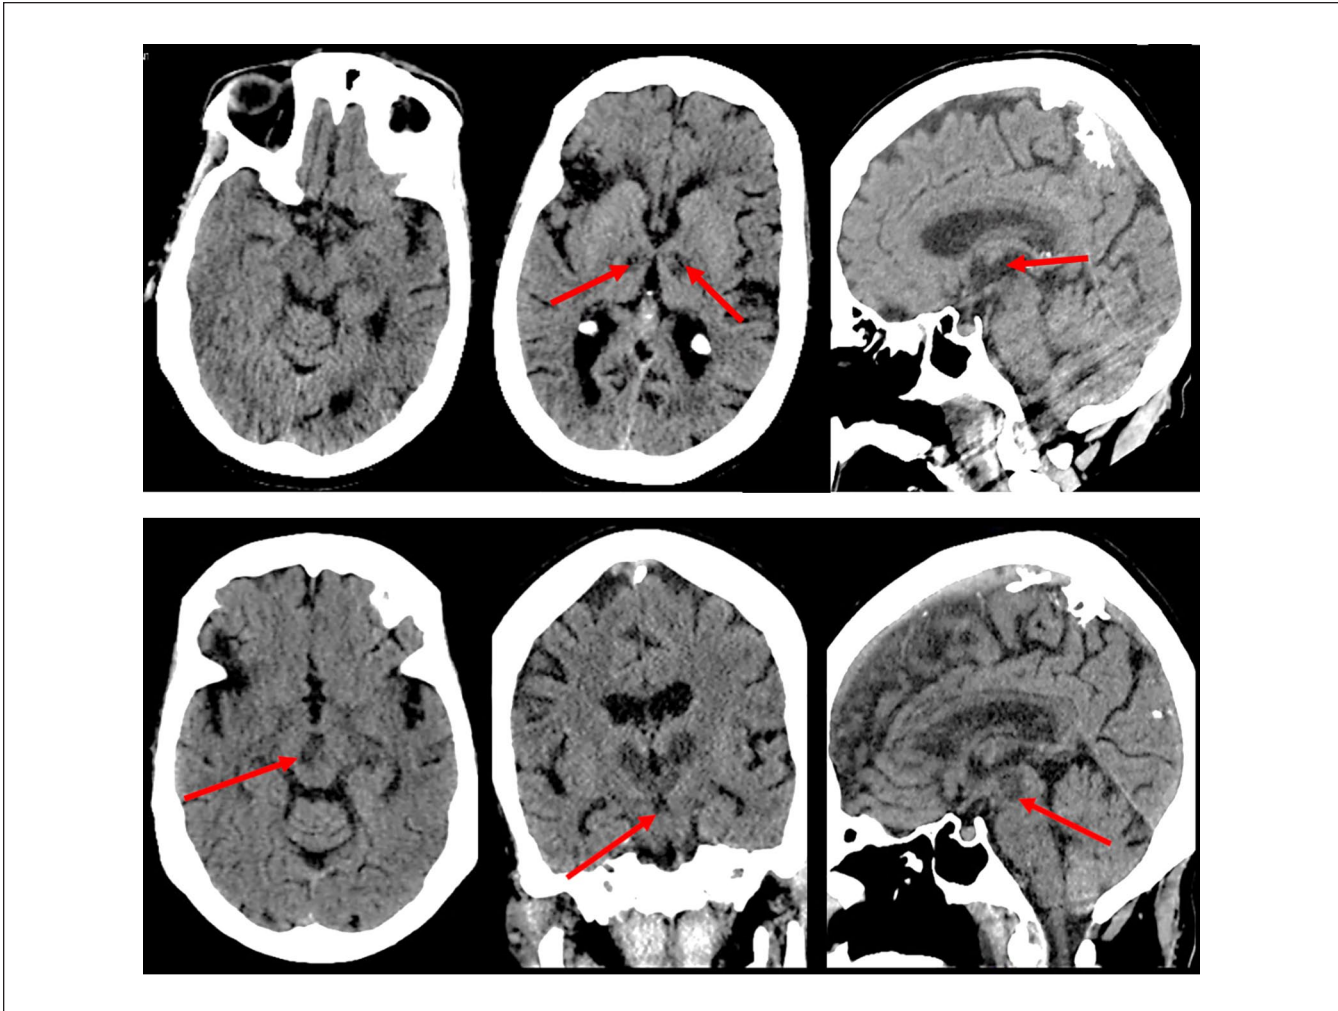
Computed tomography (CT) scan of the head on day 12 (top row), 4 hours after the onset of stupor and 1 hour after appearance of oculomotor nerve palsy, showed the previous infarct in the paramedian zones of the thalami (arrows) with no clear-cut involvement of the midbrain. Repeat CT scan of the head on day 13 (bottom row), 22 hours after the onset of stupor, showed extension of the infarct from the paramedian zones of the thalami to the paramedian zones of the midbrain with greater involvement of the right side (arrows) consistent with the clinical findings of stupor and right oculomotor nerve palsy.
